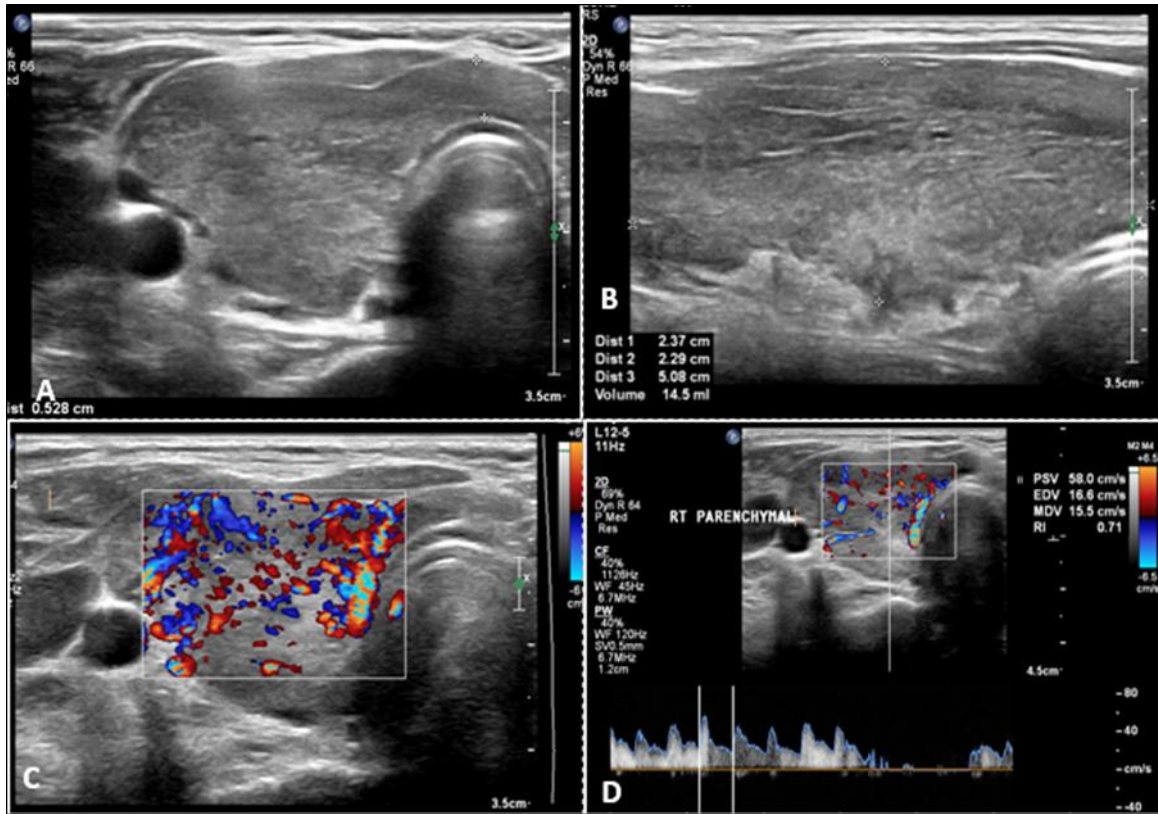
(A-D): In patient of acute early Hashimoto thyroiditis (A) & (B) shows enlarged heterogeneously hypoechoic thyroid gland with multiple tiny hypoechoic micronodules and (C) increased vascularity on colour Doppler with (D) spectral Doppler parameters
